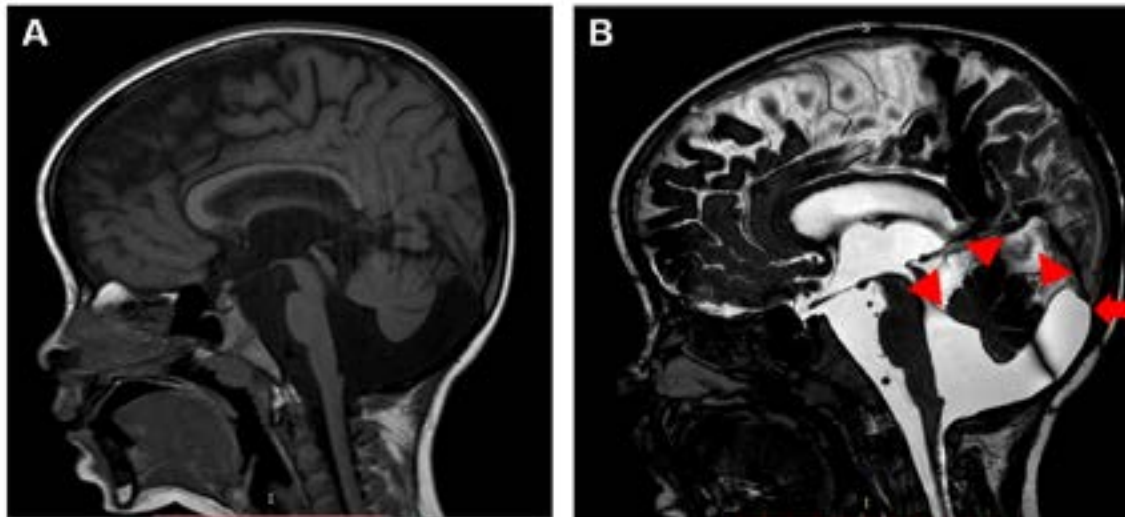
Sagittal T1 (A) and sagittal Fast Field Echo (B) brain MRI showing a cystic malformation of the posterior fossa. We highlight the normal position of *torcula herophili* (red arrow) and the normal morphology of cerebellar vermis (red arrowhead), characteristic findings of Blake's Pouch Cyst.
